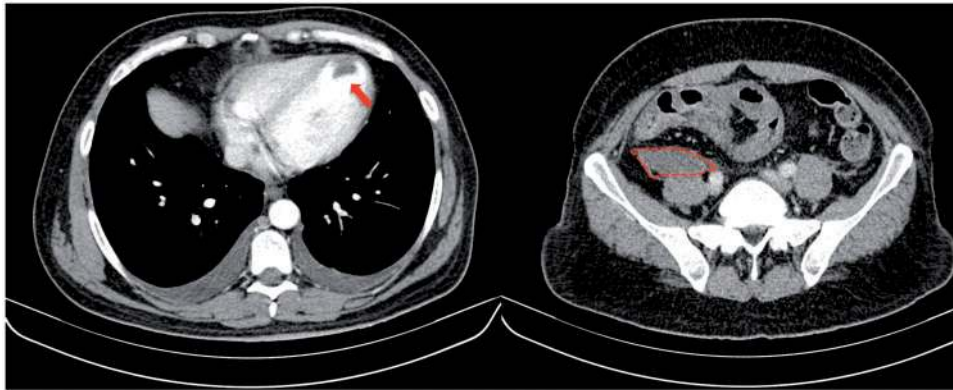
Computed tomography scan revealing persistence of the apical thrombus (left panel) and right retroperitoneal haematoma (right panel). Video available online.
